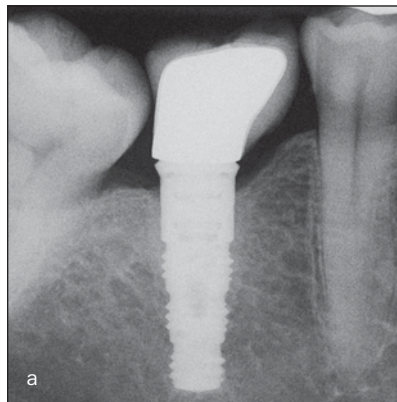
and 1b Intraoral radiographs of (a) the left implants and magnetic fasteners and (b) the right implants and fasteners in patient 1. Marginal bone resorption after at least 18 months of loading did not exceed 3 mm for 16-mm-long implants.
